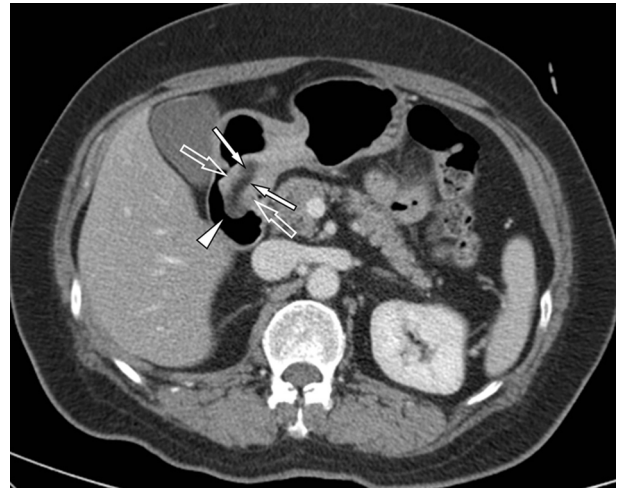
Contrast-enhanced axial CT imaging reveals an intraluminal polypoid mass in the distal antrum of the stomach with central fatty attenuation (arrows), which is covered by thickened hyper-attenuating mucosa (open arrows), except for a denuded mucosal portion (arrowhead). Note the protrusion of the mass into the duodenum.
